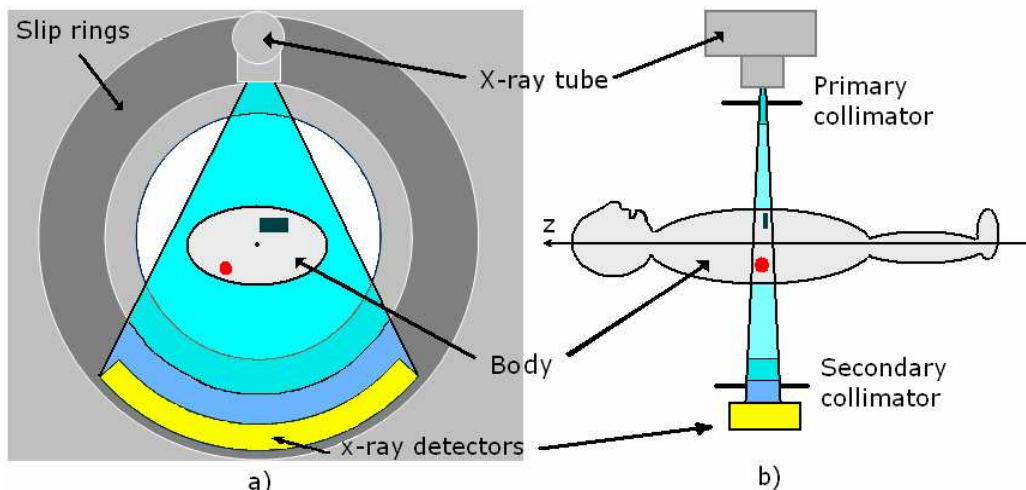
The principle of a CT seen from a) the front and b) from the side. z is the axis of rotation.
